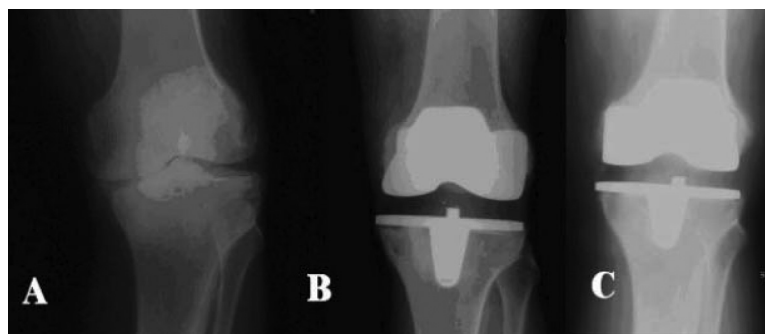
Anteroposterior radiographs shows: (A) pre-op; (B) 3 years post-op; and (C) 16 years post-op of the patient described in Case #1.
